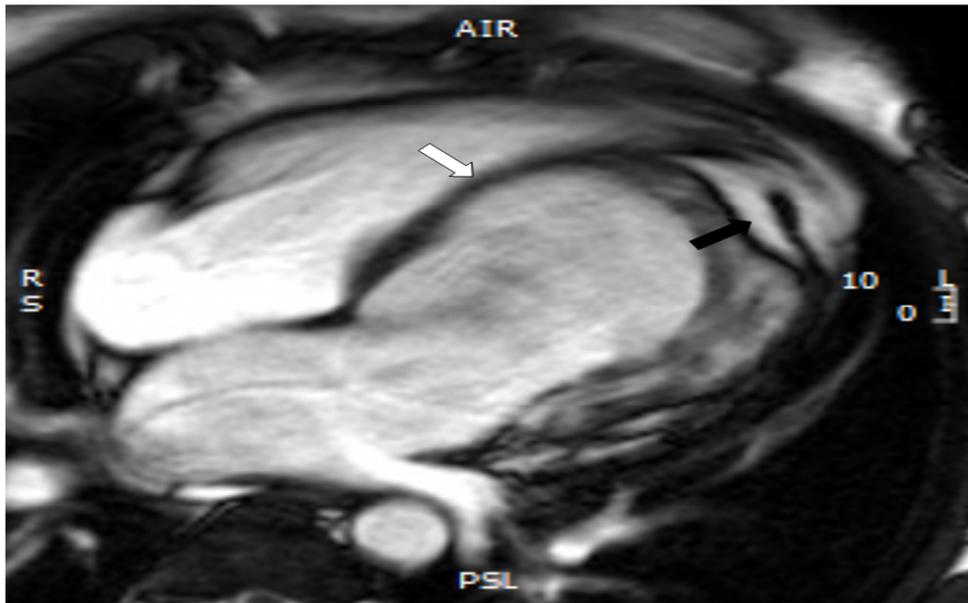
Cine cardiac magnetic resonance imaging (MRI) image in a four-chamber view shows bulging of the interventricular septum (IVS) toward the right ventricle (white arrow) and invagination of fatty material (black arrow)
